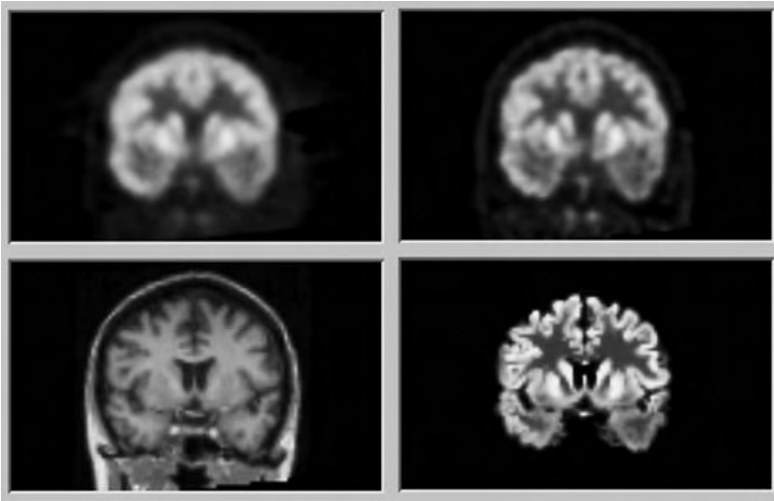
Reconstructions of a brain FDG-PET scan. *Top left*, 3D FBP. *Top right*, FORE + 2.5-D MLEM with stationary resolution recovery. *Bottom left*, registered MR-image. *Bottom right*, FORE + 2.5-D MAP with an anatomical prior based on the MRI
